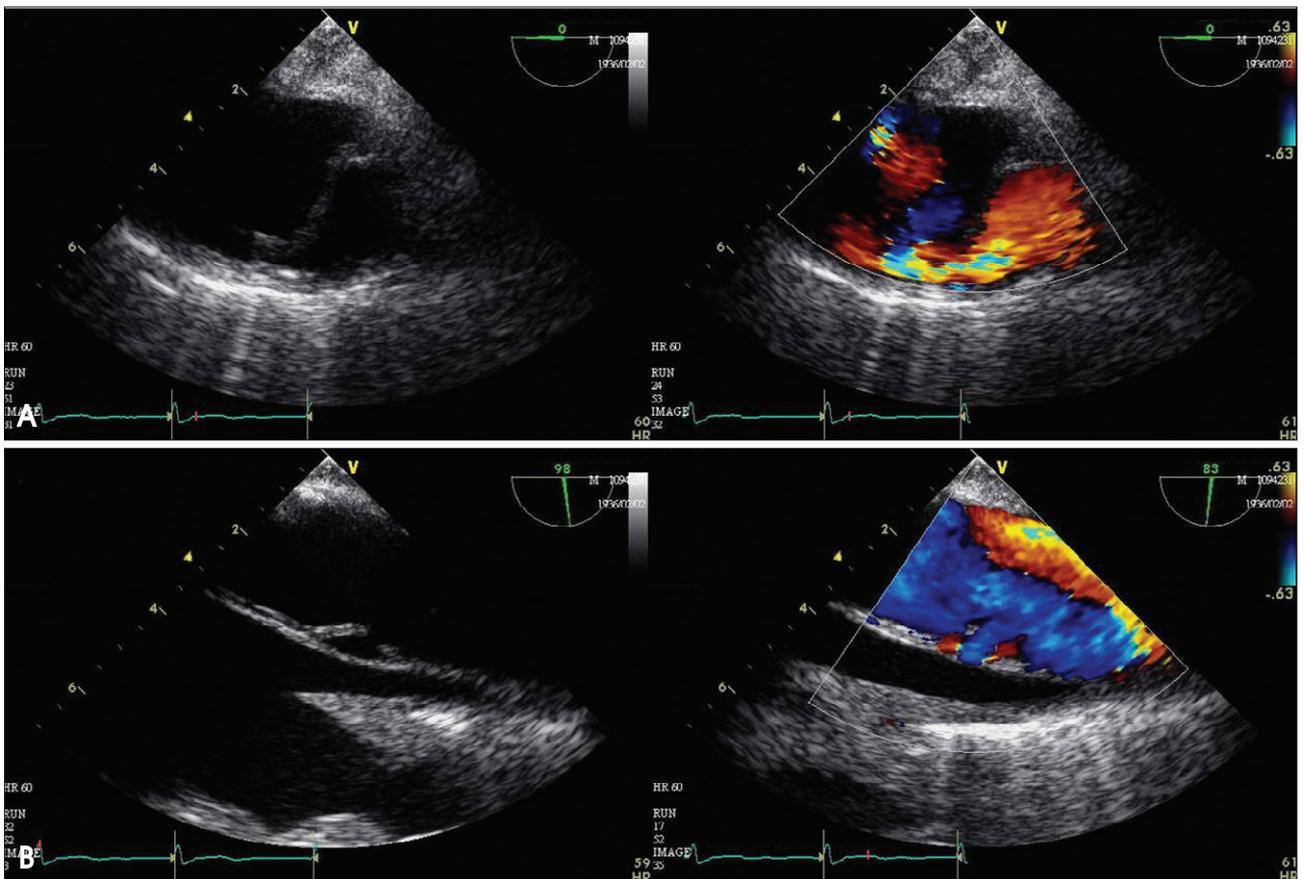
Transesophageal echocardiography, color Doppler. Proximal dissection (A), distal dissection (B).
